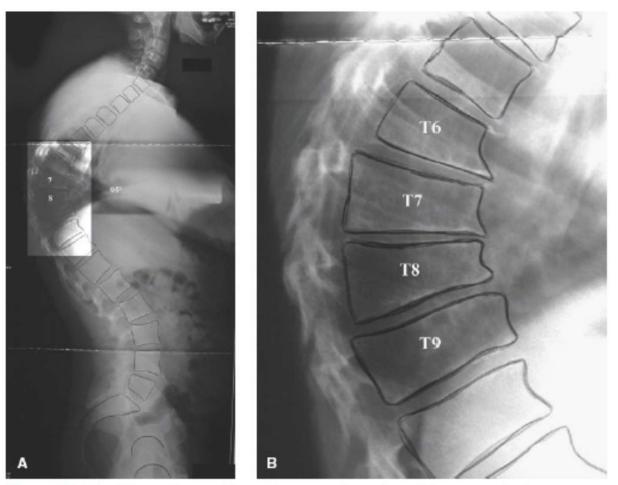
A: AB is a 45-year-old man showing a classic large Scheuermann kyphosis with apex at disc T7–T8. The curve is 95 degrees across the Cobb angle measurements from T4 to T11. The apical four vertebras are wedged. B: Close-up view shows the elongated anterior to posterior dimension of the apical vertebral bodies, the wedging, and the anterior osteophytic deformations typical of Scheuermann deformity.
